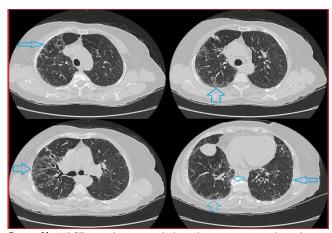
HRCT revealing ground-glass densities, traction bronchiectasis, ground-glass densities, mosaic perfusion and air trapping areas mostly in the middle lung fields
